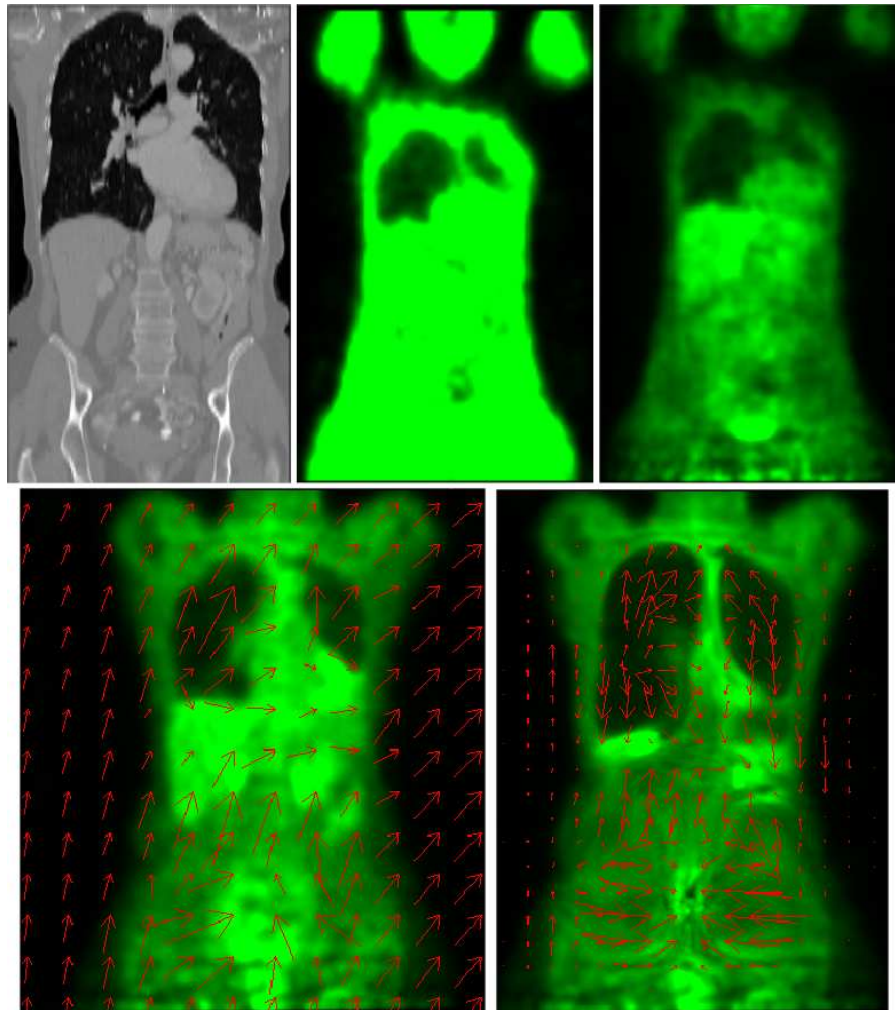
Results obtained by computing an affine + FFD transformation between CT and emission PET images. Top: CT (left) transmission (center) and emission PET (right) original images. Bottom: registered emission PET images obtained by applying affine (left) and affine+FFD (right) transformations. The displacement field (red arrows) associated to each one of these transformations (affine on the left and FFD on the right) is superimposed on the images. These results prove the difficulties of this approach to deal with the particular characteristics of our application.
